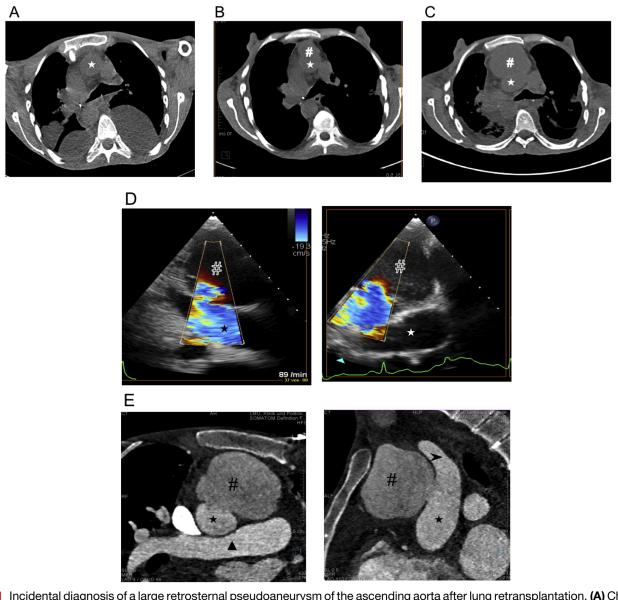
Incidental diagnosis of a large retrosternal pseudoaneurysm of the ascending aorta after lung retransplantation. (A) Chest CT scan 1 month after retransplantation showing normal mediastinal conditions. (B, C) Chest CT scan 5 (B) and 7 months (C) after retransplantation showing a rapidly progressive retrosternal mass in the mediastinum. (D) Color-coded echocardiography showing perfusion of a pseudoaneurysm originating from the ascending aorta with a broad aneurysmal neck. (E) CT angiography of the thorax confirming a pseudoaneurysm of the ascending aorta at the site of aortic cannulation. The *star* (\star) shows the ascending aorta; the *pound sign* (#) shows the pseudoaneurysm; the *triangle* (\blacktriangle) shows the main pulmonary artery; and the *arrow* (\succ) shows the brachiocephalic trunk.
